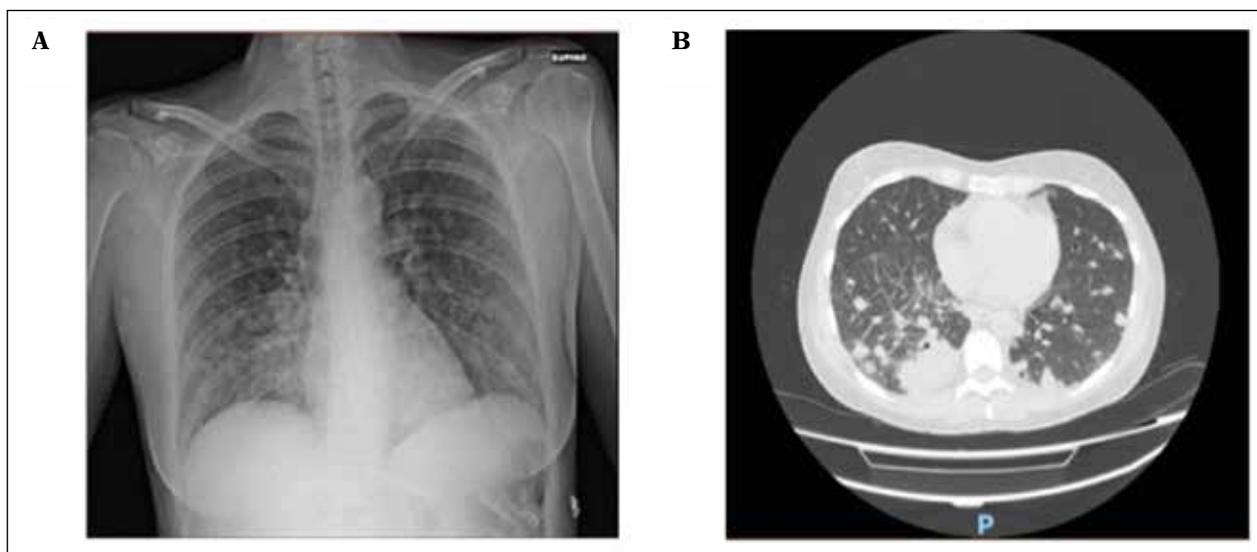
Chest radiography thickening and computed tomography images. Chest X-ray shows bilateral basal thickenings, while multiple nodular lesion were detected by CT scan.
